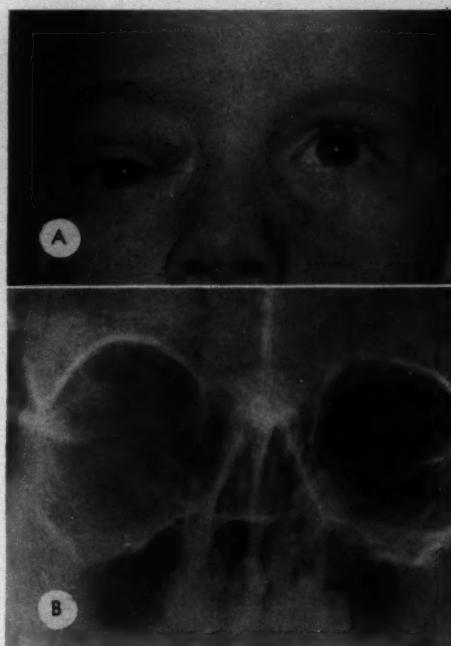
(Jones). Case 43. (A) Exophthalmos and presenting tumor due to blood cyst in an orbital cystic lymphangioma. (B) X-ray film, showing orbital enlargement in same case.
